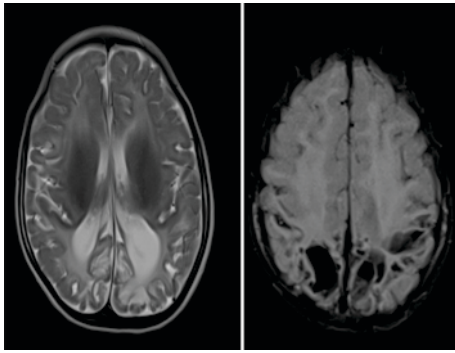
MRI T2 and FLAIR axial images showing Gliosis, porencephalic cyst, dilated ventricle, neuroparenchymal volume loss and non visualization of posterior body and splenium of corpus callosum.
